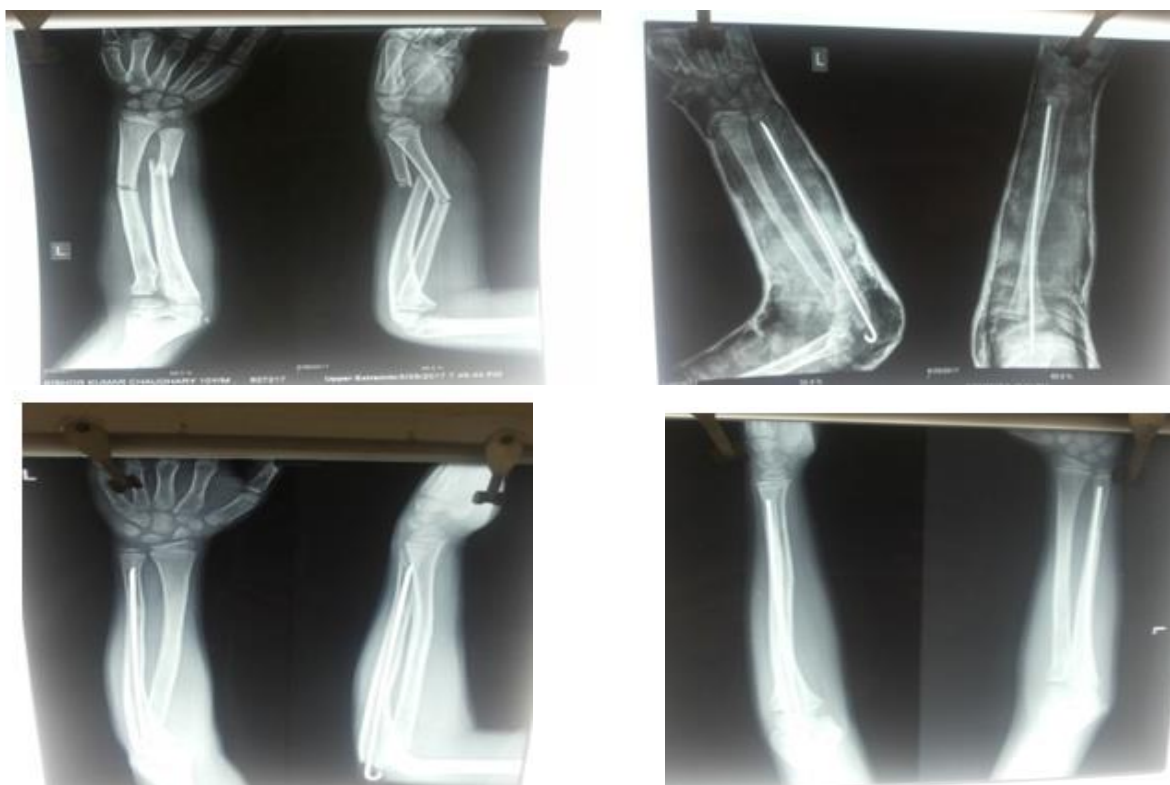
Immediate and follow-up X-rays of both-bone forearm fracture with Rush pin in situ with A/E Cast
